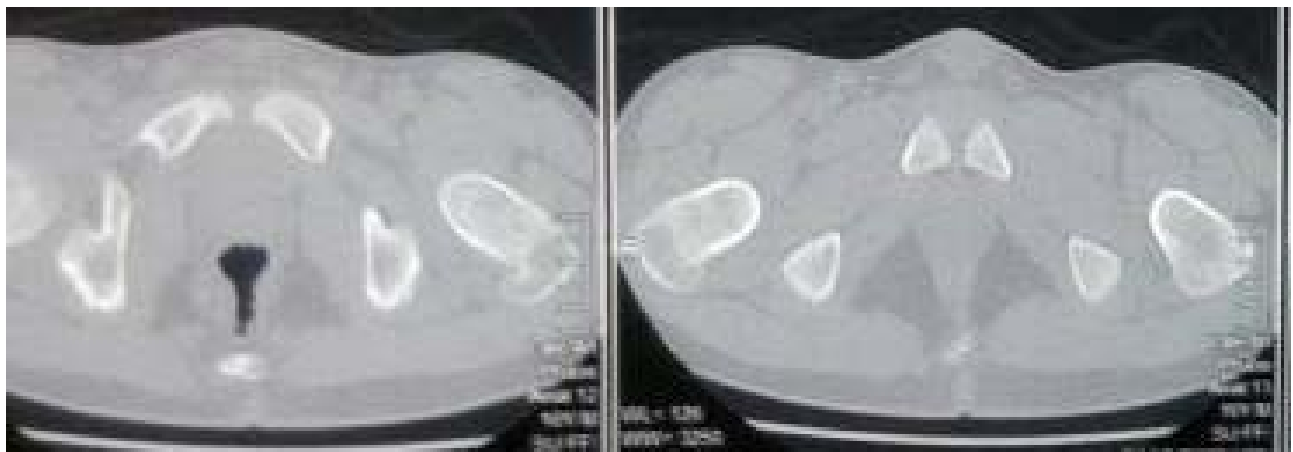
preoperative CT scan showing deficient acetabular coverage and increased femoral anteversion angle.
